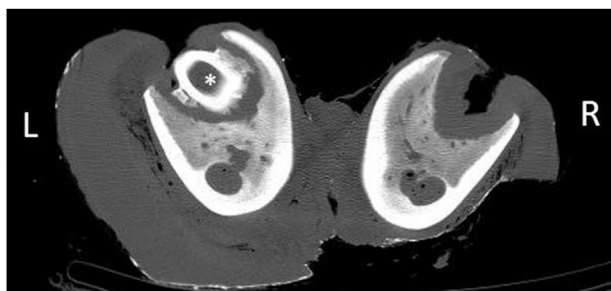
Transverse CT image showing tooth L7 (L) and the empty alveolus of tooth R7 (R), which demonstrates no evidence of remodelling. Tooth L7 shows failure of the pulp cavity to narrow (consistent with tooth death at a relatively immature age), generalized widening of the periodontal space with evidence of pulp necrosis or irreversible pulpitis, irregular radicular proliferation (white asterisk) and embedding/impaction (as evidenced by lack of protrusion of the intact crown past the gingival margin).
